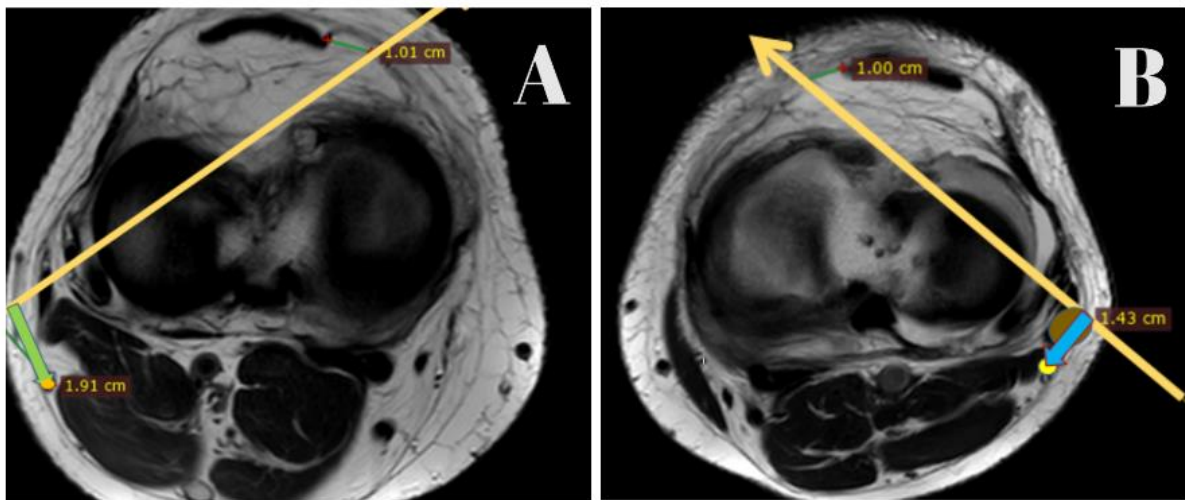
Axial MRI images comparing a normal knee (A) with an ACL-injured knee (B), demonstrating our measurement method
